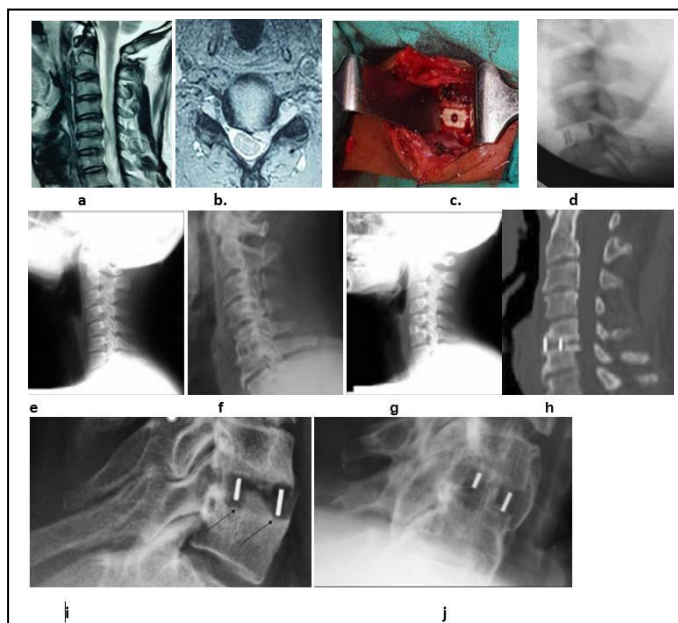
a, b- Pre-operative MRI (sagittal and axial view), c, d- Per-operative pic and immediate post-operative lateral view x-ray. e, f, g, h- pre operative x-ray and at 3 months, 12 months post-operative x-ray and CT scan showing fusion, i- At 24 months follow up shows union and subsidence of a PEEK -cage into the posterior part of the inferior endplate of 45 yr. old male.
